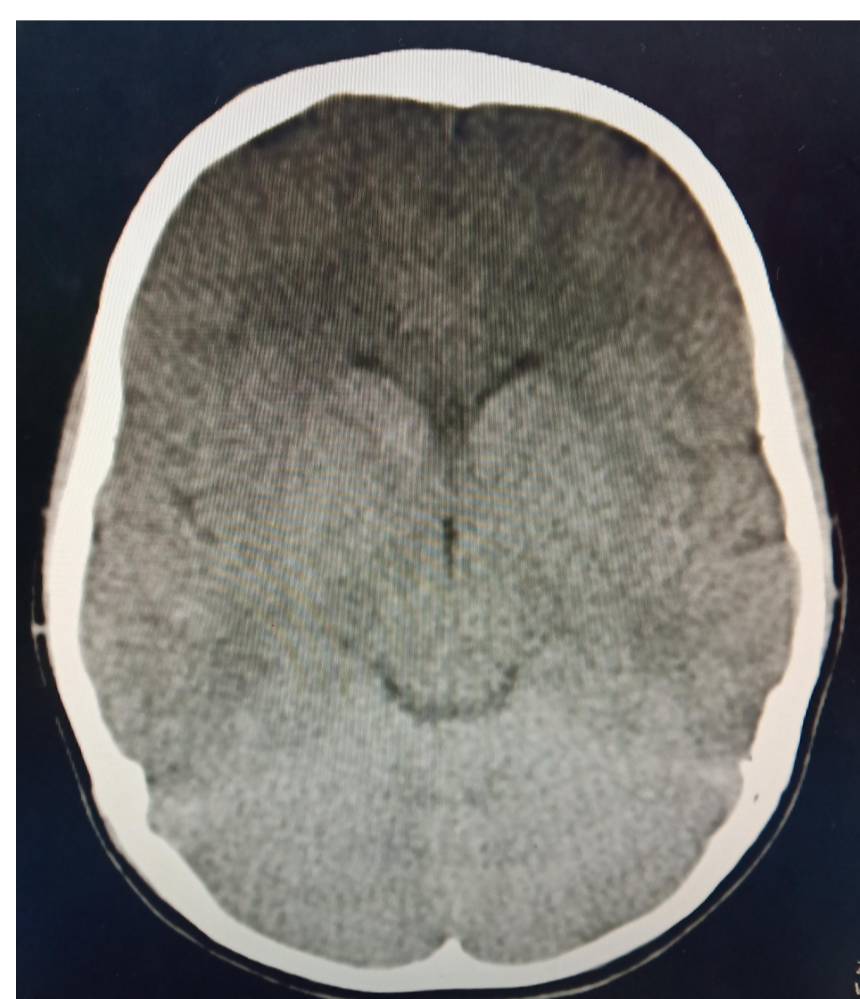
CT brain shows no abnormality on admission.
